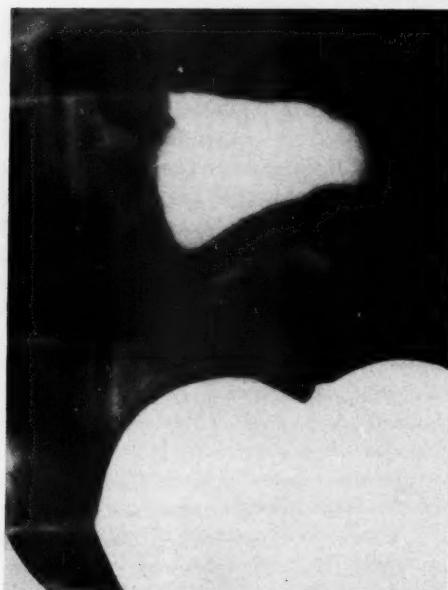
Spot roentgenogram demonstrating normal duodenal bulb in the upright position
